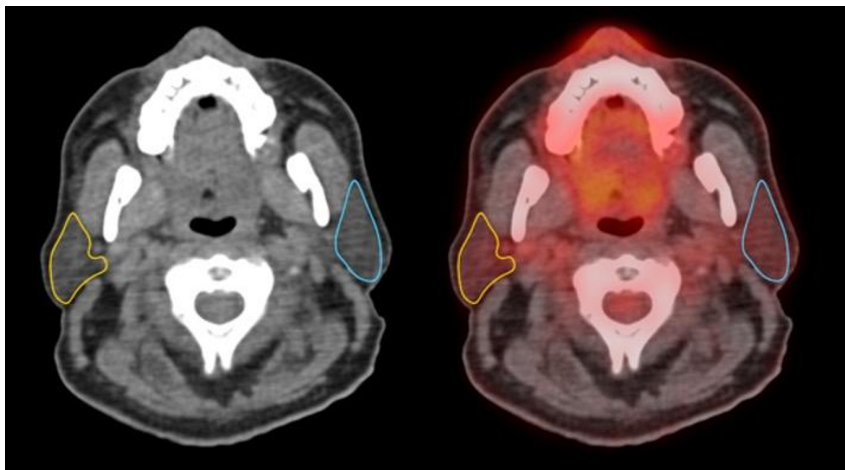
Example of axial ^{18}F -FDG PET/CT images with bilateral parotid gland regions of interest (outlined in blue and yellow) used for SUV quantification.
